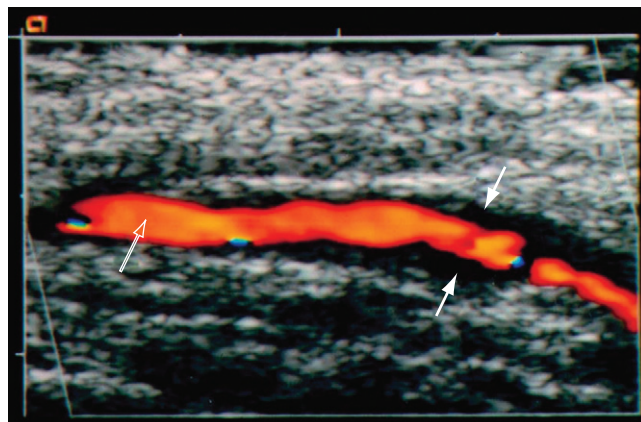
Color duplex ultrasound examination of a swollen, tender temporal artery in a patient with giant cell arteritis. The variably thickened artery wall is visible as a clear “halo” (solid arrows) around the lumen in the center (open arrow). (Courtesy Dr. Gene Hunder.)
